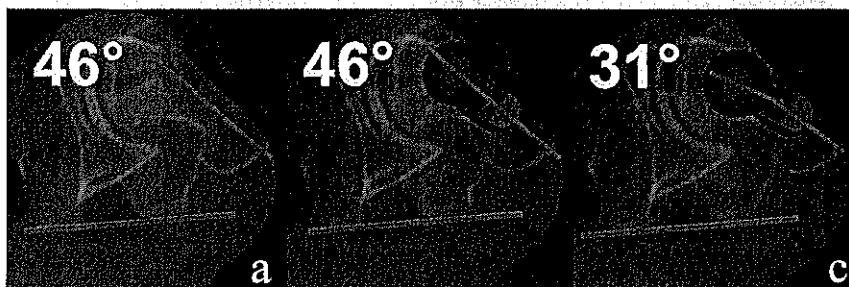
a) Two superimposed CT scan slices of a DDH case showing a highly pathological femoral neck anteversion. b) a straight neck does not allow an anatomic reconstruction. c) a 15° retroverted neck allows the correction of the deformity.
